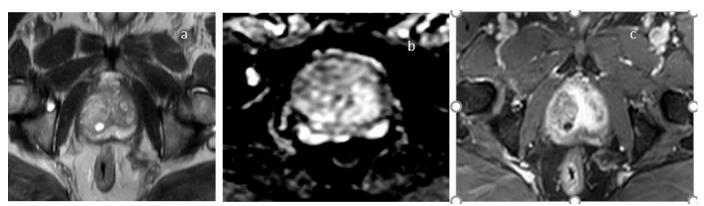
A 66-year-old man with increased prostate-specific antigen level of 11 ng/mL. The result of non-targeted biopsy was negative. Subsequent magnetic resonance imaging revealed an enlarged prostate gland with an approximate volume of 178 mL. However, no T2-hypointense lesion (a) was seen with corresponding low signal on apparent diffusion coefficient maps (b) or abnormal post-contrast enhancement (c). A small circumscribed lesion seen in the right transition zone (a) did not show restricted diffusion or abnormal enhancement in subsequent images and was most consistent with a cystic benign prostatic hyperplasia nodule. A Prostate Imaging Reporting and Data System score of 2 was assigned.
